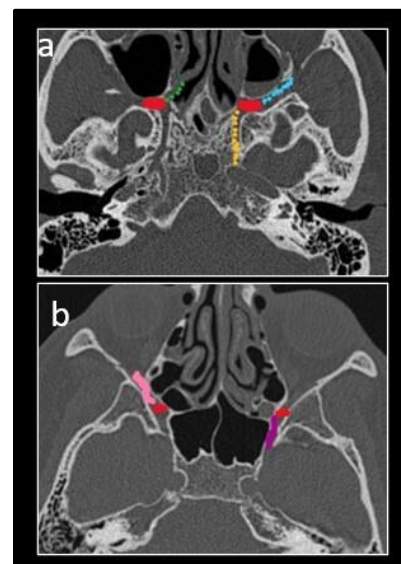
a and b depict the CT anatomy of the pterygopalatine fossa and its connections in the axial plane.
